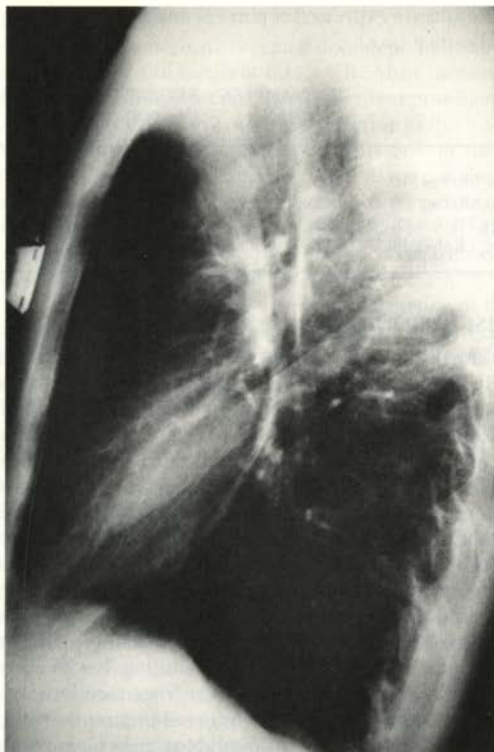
Left lateral x-ray of dislodged ICVAD in chest before removal.
